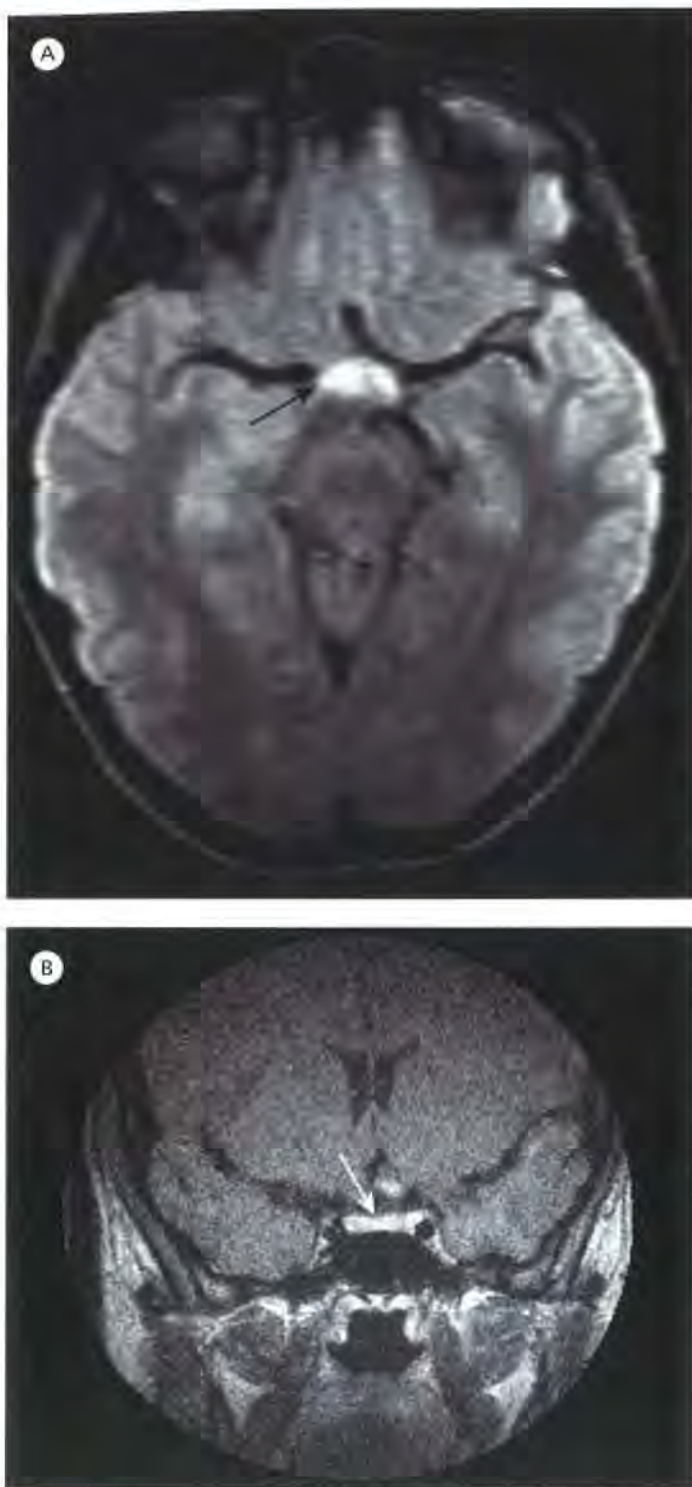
Chiasmal involvement in optic neuritis (arrows). (A) T₂-weighted MRI. (B) Gadolinium enhanced T₁-weighted MRI.
